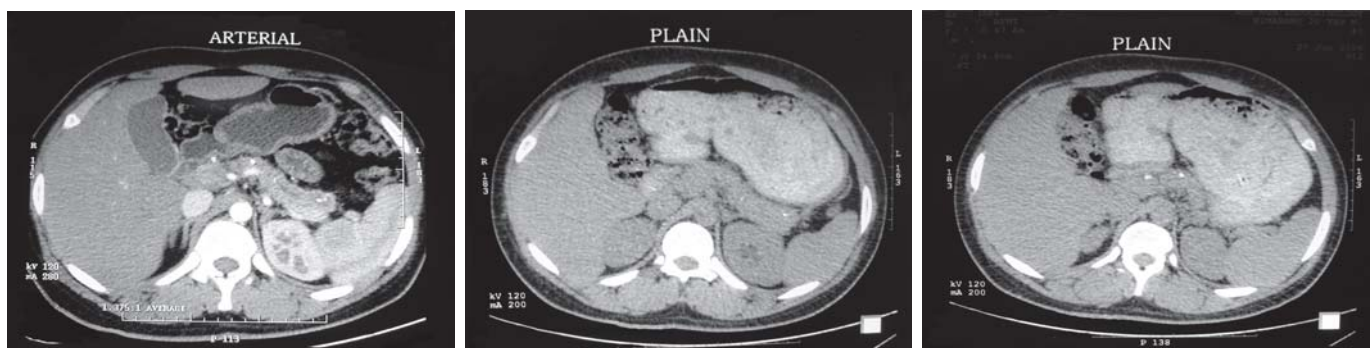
Abdominal CT scan before the first operation
